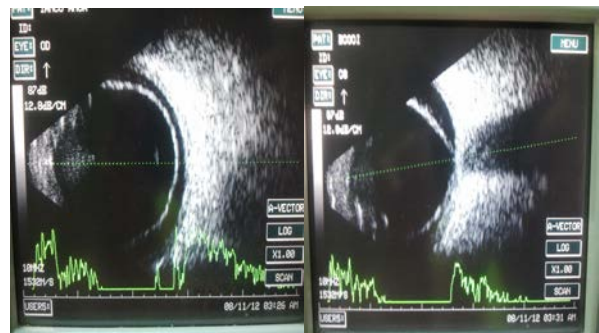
Ultrasound aspects in right eye (a) and left eye (b): total retinal detachment
